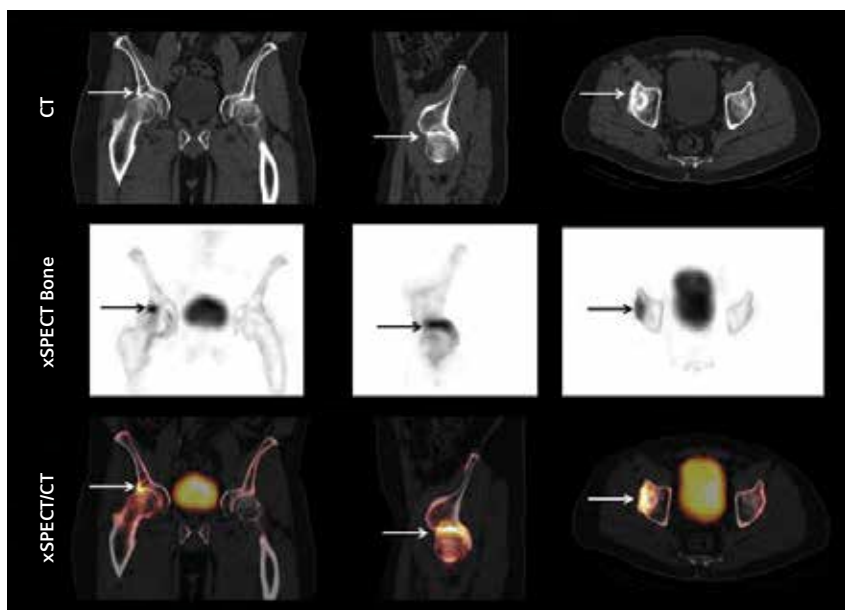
CT, xSPECT Bone and fused CT and xSPECT Bone show increased uptake of tracer in the right acetabular labrum (arrows), which also shows irregularities in the acetabular margin and small bony fragments of the acetabular labrum, suggestive of an acetabular labral tear.
